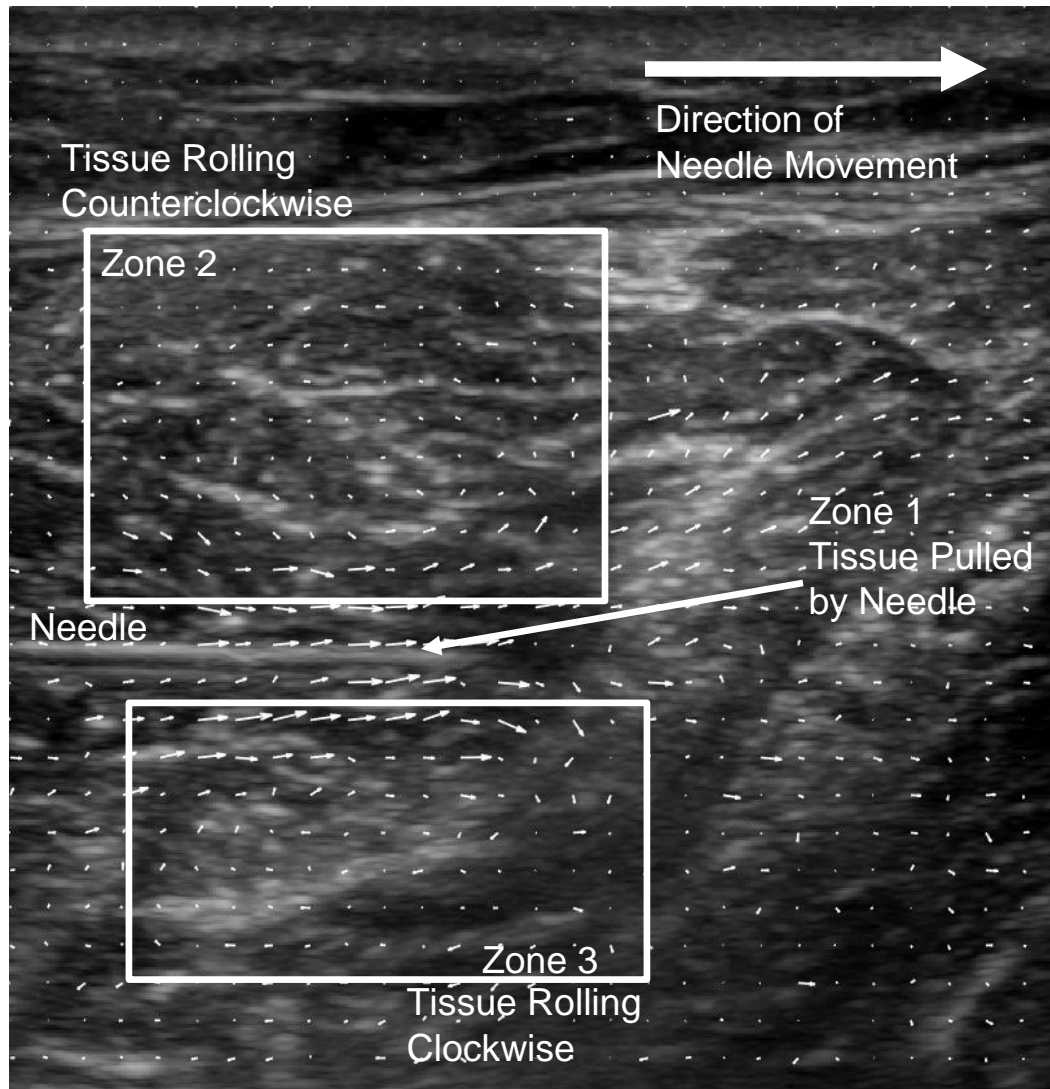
Ultrasound image from a needle insertion into the thigh of a cadaver with the vector field showing tissue movement for 2 video frames overlaid. Three distinct zones of tissue movement are highlighted.
